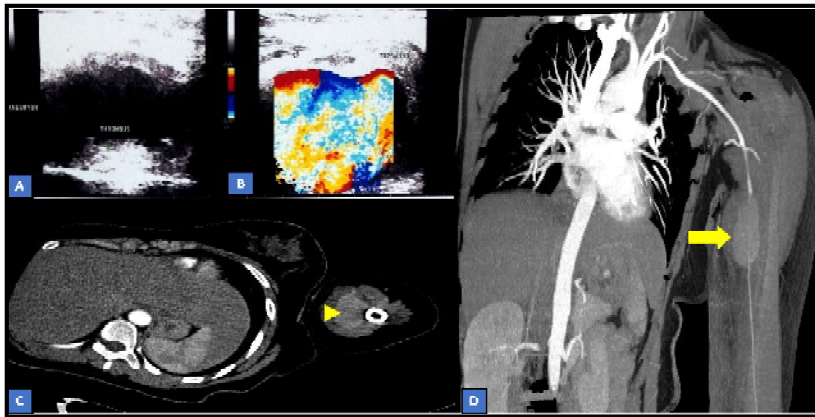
Left brachial artery aneurysm imaging (A) USG showing the aneurysm with a thrombus in situ, (B) Colour doppler showing turbulent flow in the aneurysmal dilatation, (C) Transverse CT section with arrow head marking the aneurysm, (D) Longitudinal CT section with arrow marked aneurysmal dilatation
